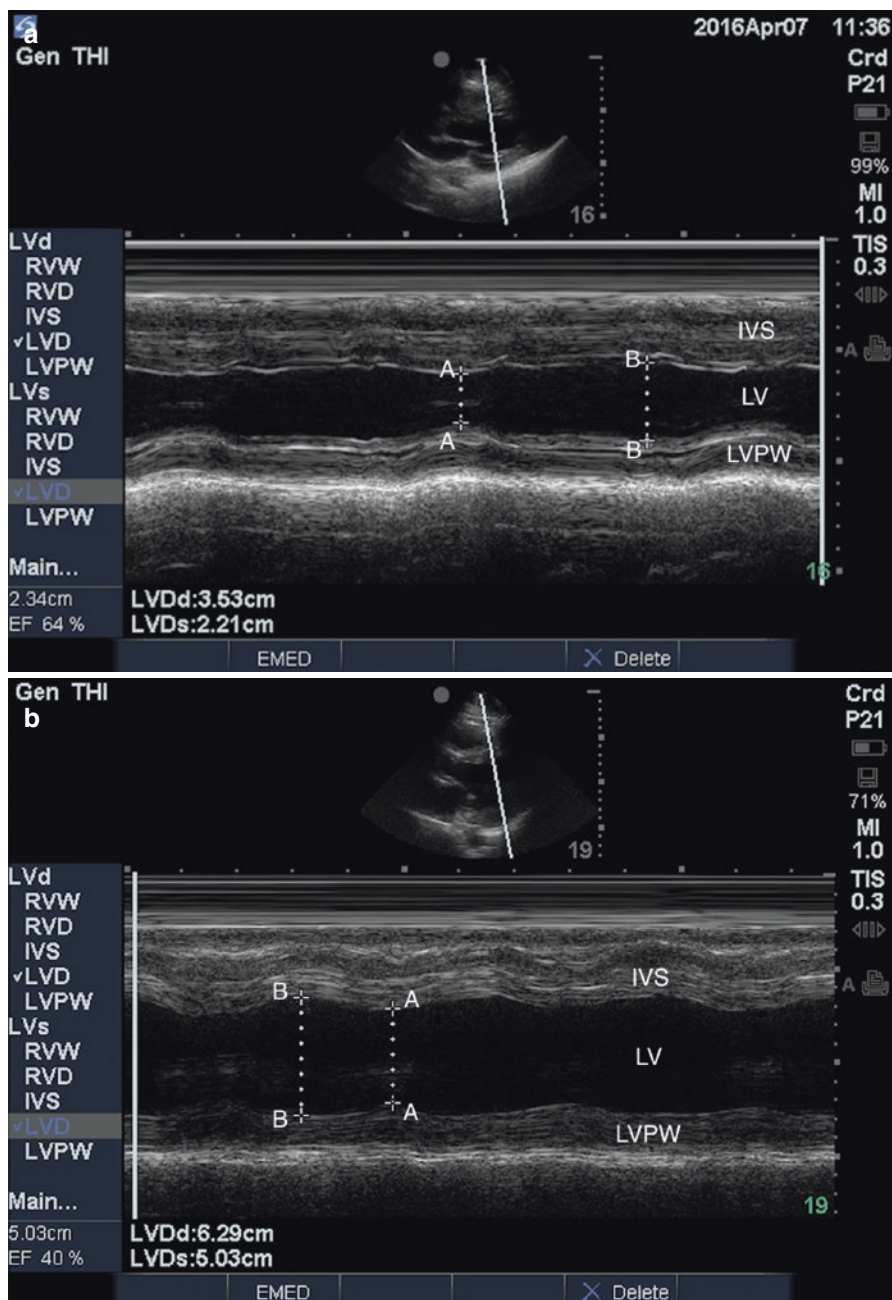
(a, b) (FS nml, abnml). Fractional shortening (FS) is the use of M-mode in the parasternal long cardiac window to measure the degree of left ventricle (LV) chamber shortening between diastole and systole. FS is expressed as a percentage by calculating the difference between end-diastolic LV diameter and end-systolic LV diameter. The difference is then divided by the end-diastolic LV diameter and multiplied by 100. Some ultrasound machines possess software that will convert FS% into EF as is recorded in this image. *IVS* interventricular septum, *LV* left ventricle, *LVPW* left ventricle posterior wall, *A to A* LV end-systolic diameter, *B to B* left ventricle end-diastolic diameter
